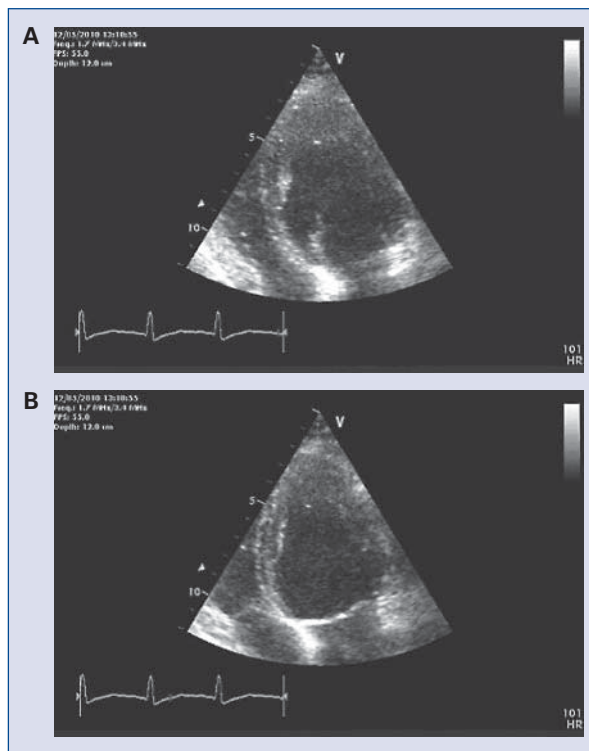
Apical four-chamber view of patient during left ventricular diastole (A) and systole (B) in acute phase.
